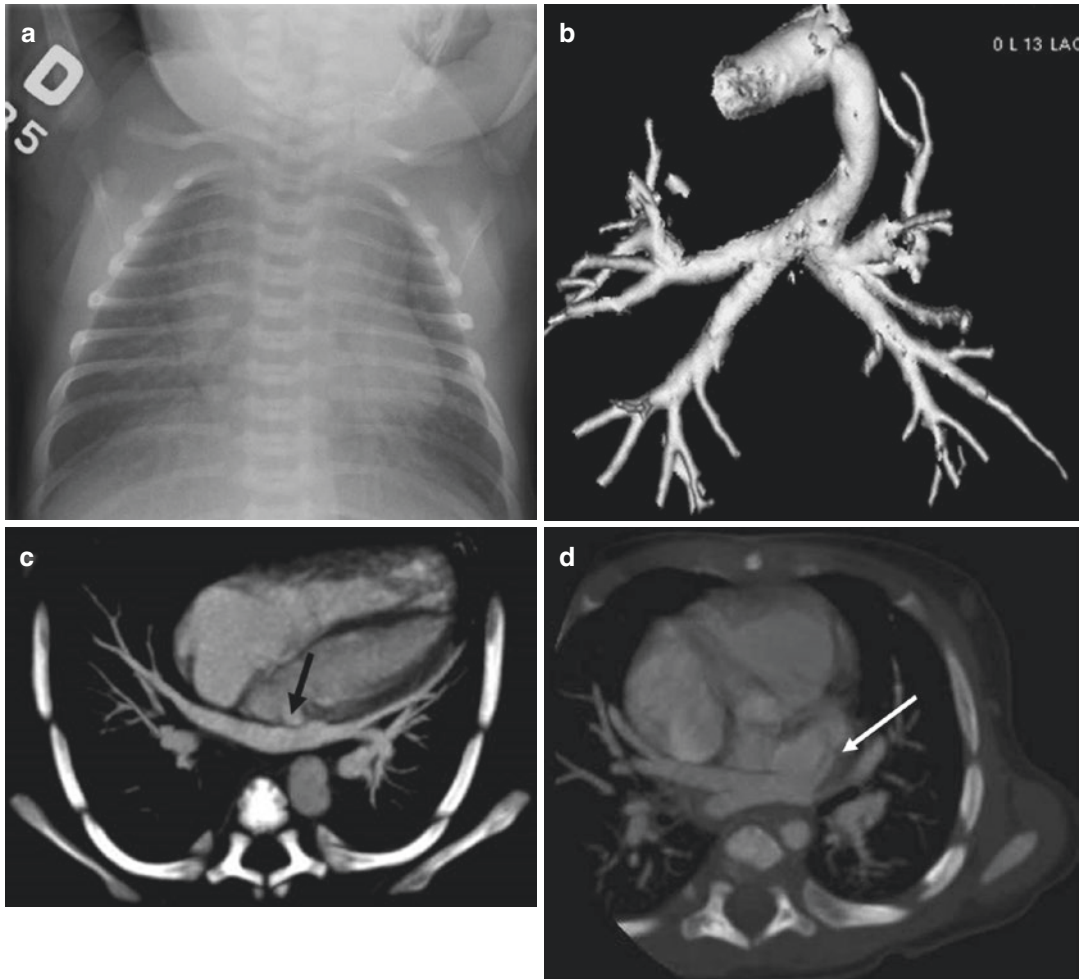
Supracardiac type of total anomalous pulmonary venous return (type 1). (a) Frontal chest radiograph shows an enlargement of superior mediastinum snowman shape and increased pulmonary arterial vascularization. (b) Anterior volume rendering image from CT angiography shows all pulmonary veins draining into common pulmonary vein that connects to left brachiocephalic vein through a vertical vein. (c) Four-chamber view thin
